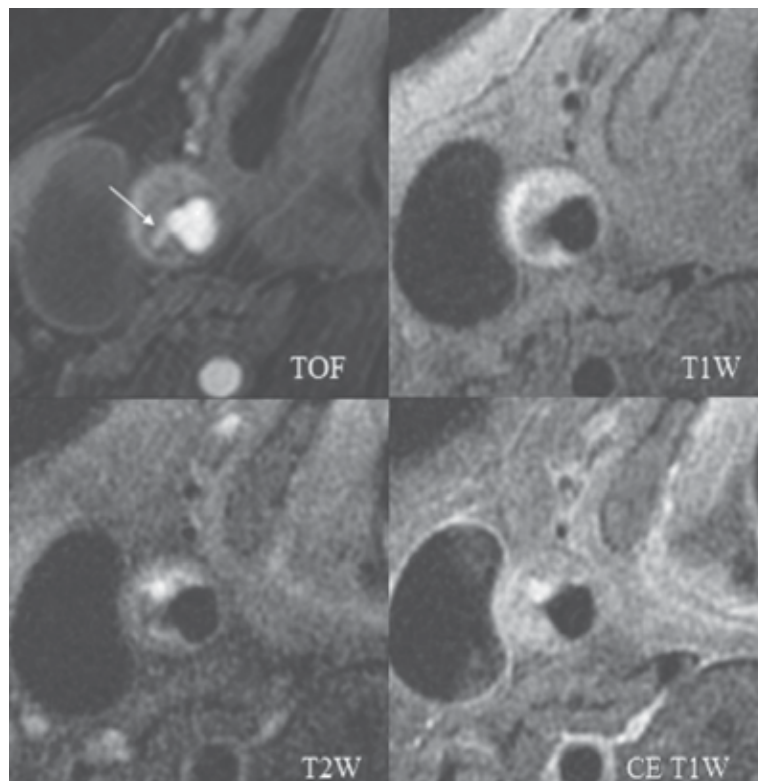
Identification of intra-plaque haemorrhage using high spatial resolution, multi-contrast MRI image. (*JACC Cardiovasc Imaging*. 2009; 2:883-96.)
